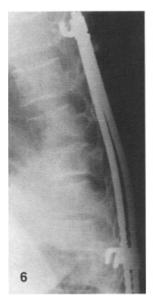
Postoperative lateral radiograph of the spine: kyphosis has been corrected
